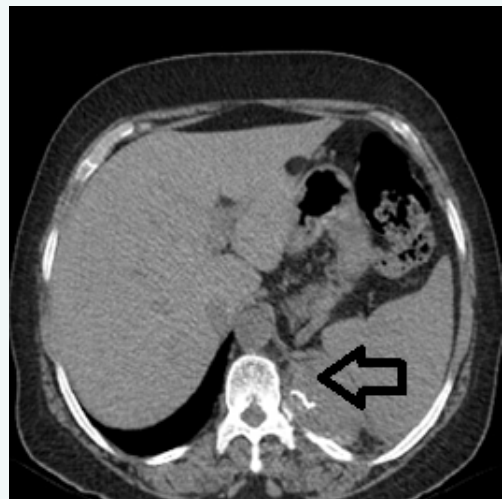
CT-scan of the chest which shows a mass in the left side over diaphragm in the paravertebral sulcus.
